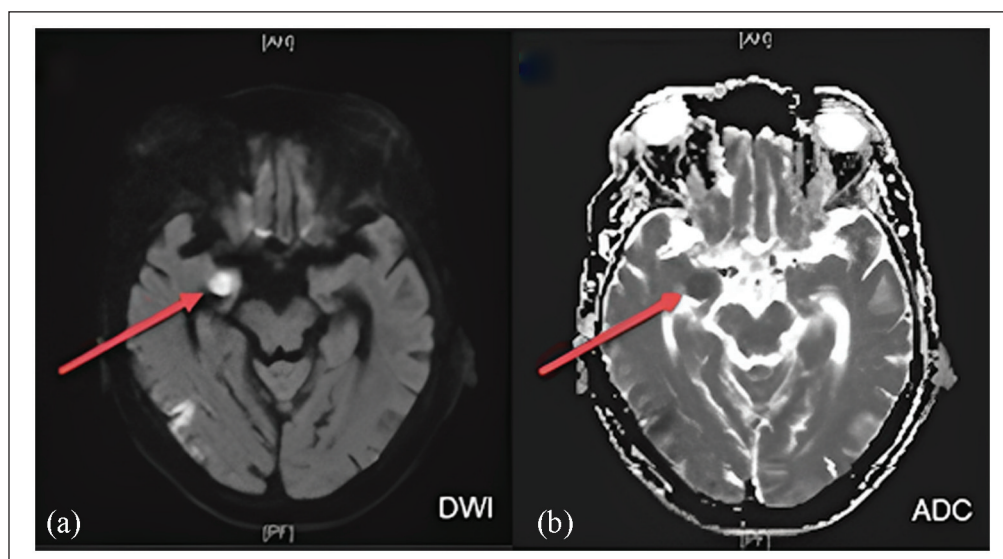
(a) Brain MRI diffusion weighted imaging (DWI). (b) Corresponding low apparent diffusion coefficient (ADC) values. Both panels refer to Day 2 after stroke and show exemplary ischaemic lesions in right amygdala (red arrows). MRI: Magnetic Resonance Imaging.
